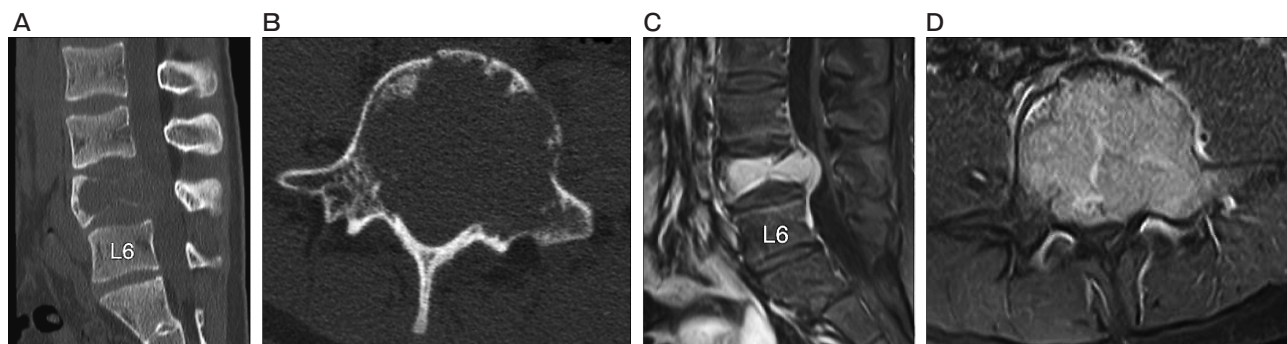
Preoperative computed tomography scan revealing a pathological compression fracture of the L5 vertebral body and osteolytic lesion (A, B). Gadolinium-enhanced T1-weighted magnetic resonance image showing marked enhancement and an extra-compartmental extension of the tumor with canal occupation (C, D).
